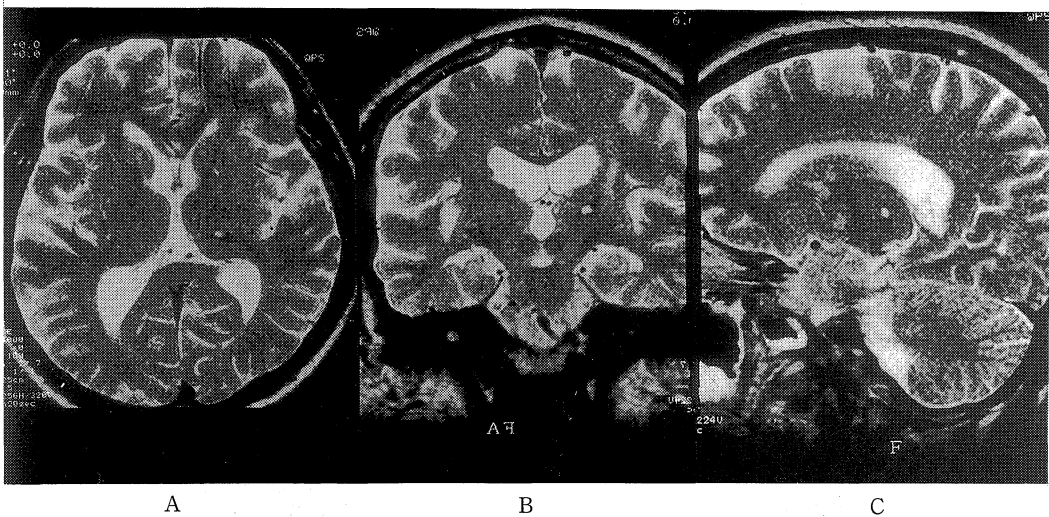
Axial (A), coronal (B) and sagittal (C) magnetic resonance imagings (MRI) demonstrate a very small spotty high intensity on T2 weighted images in the left ventral posterolateral nucleus of the thalamus.
